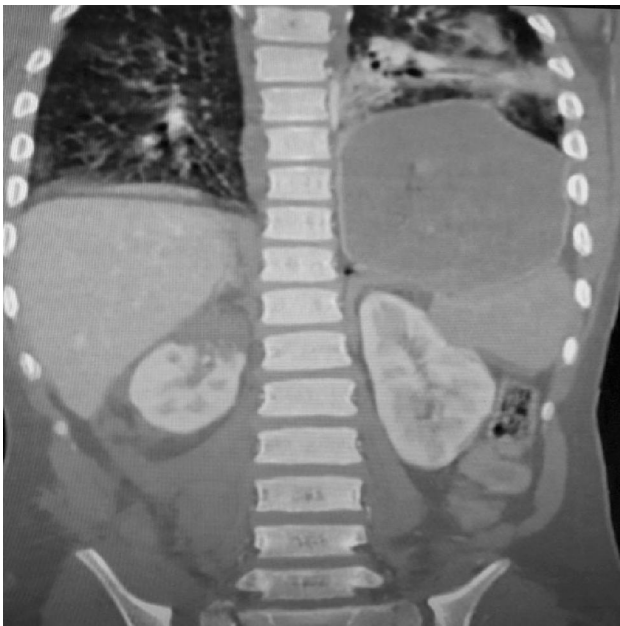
Coronal section of CT abdomen showing defect in the left diaphragm with a small speck of free air representing pneumoperitoneum. Intrathoracic herniation of stomach and right renal contusion also seen.
